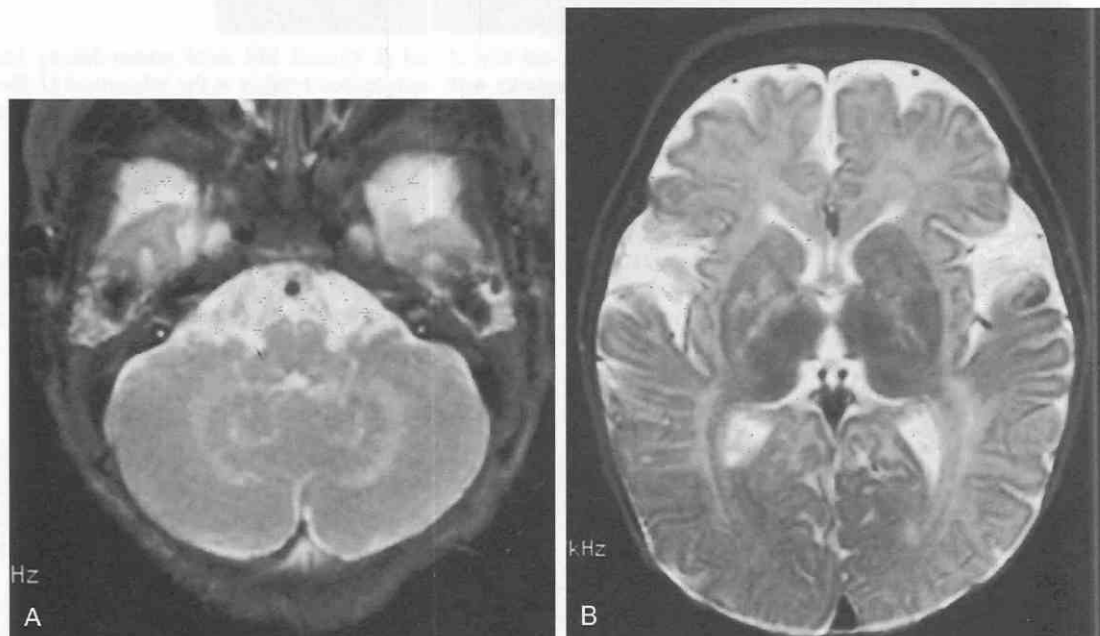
Globoid cell leukodystrophy (Krabbe's disease) in a 5-month-old infant with total body spasticity and high levels of protein in the cerebrospinal fluid. T2-weighted axial MR images. *A*, Abnormal high intensity cerebellar white matter changes. *B*, There is both white matter generalized hyperintensity as well as early T2 hyperintensity in the deep gray matter nuclei (lenticular nuclei, thalami).
